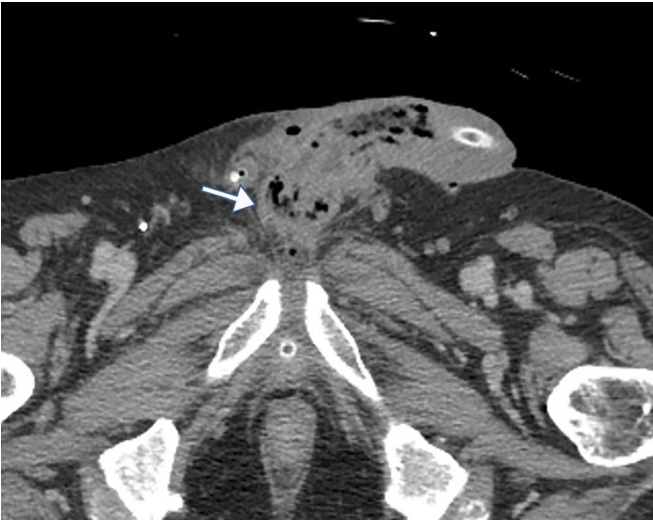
Penile prosthesis explant in a 72-year-old man. Axial contrast-enhanced CT of the pelvis at the level of the base of the penis demonstrates extensive air (arrow) within the penile parenchyma, mimicking penile abscess.
